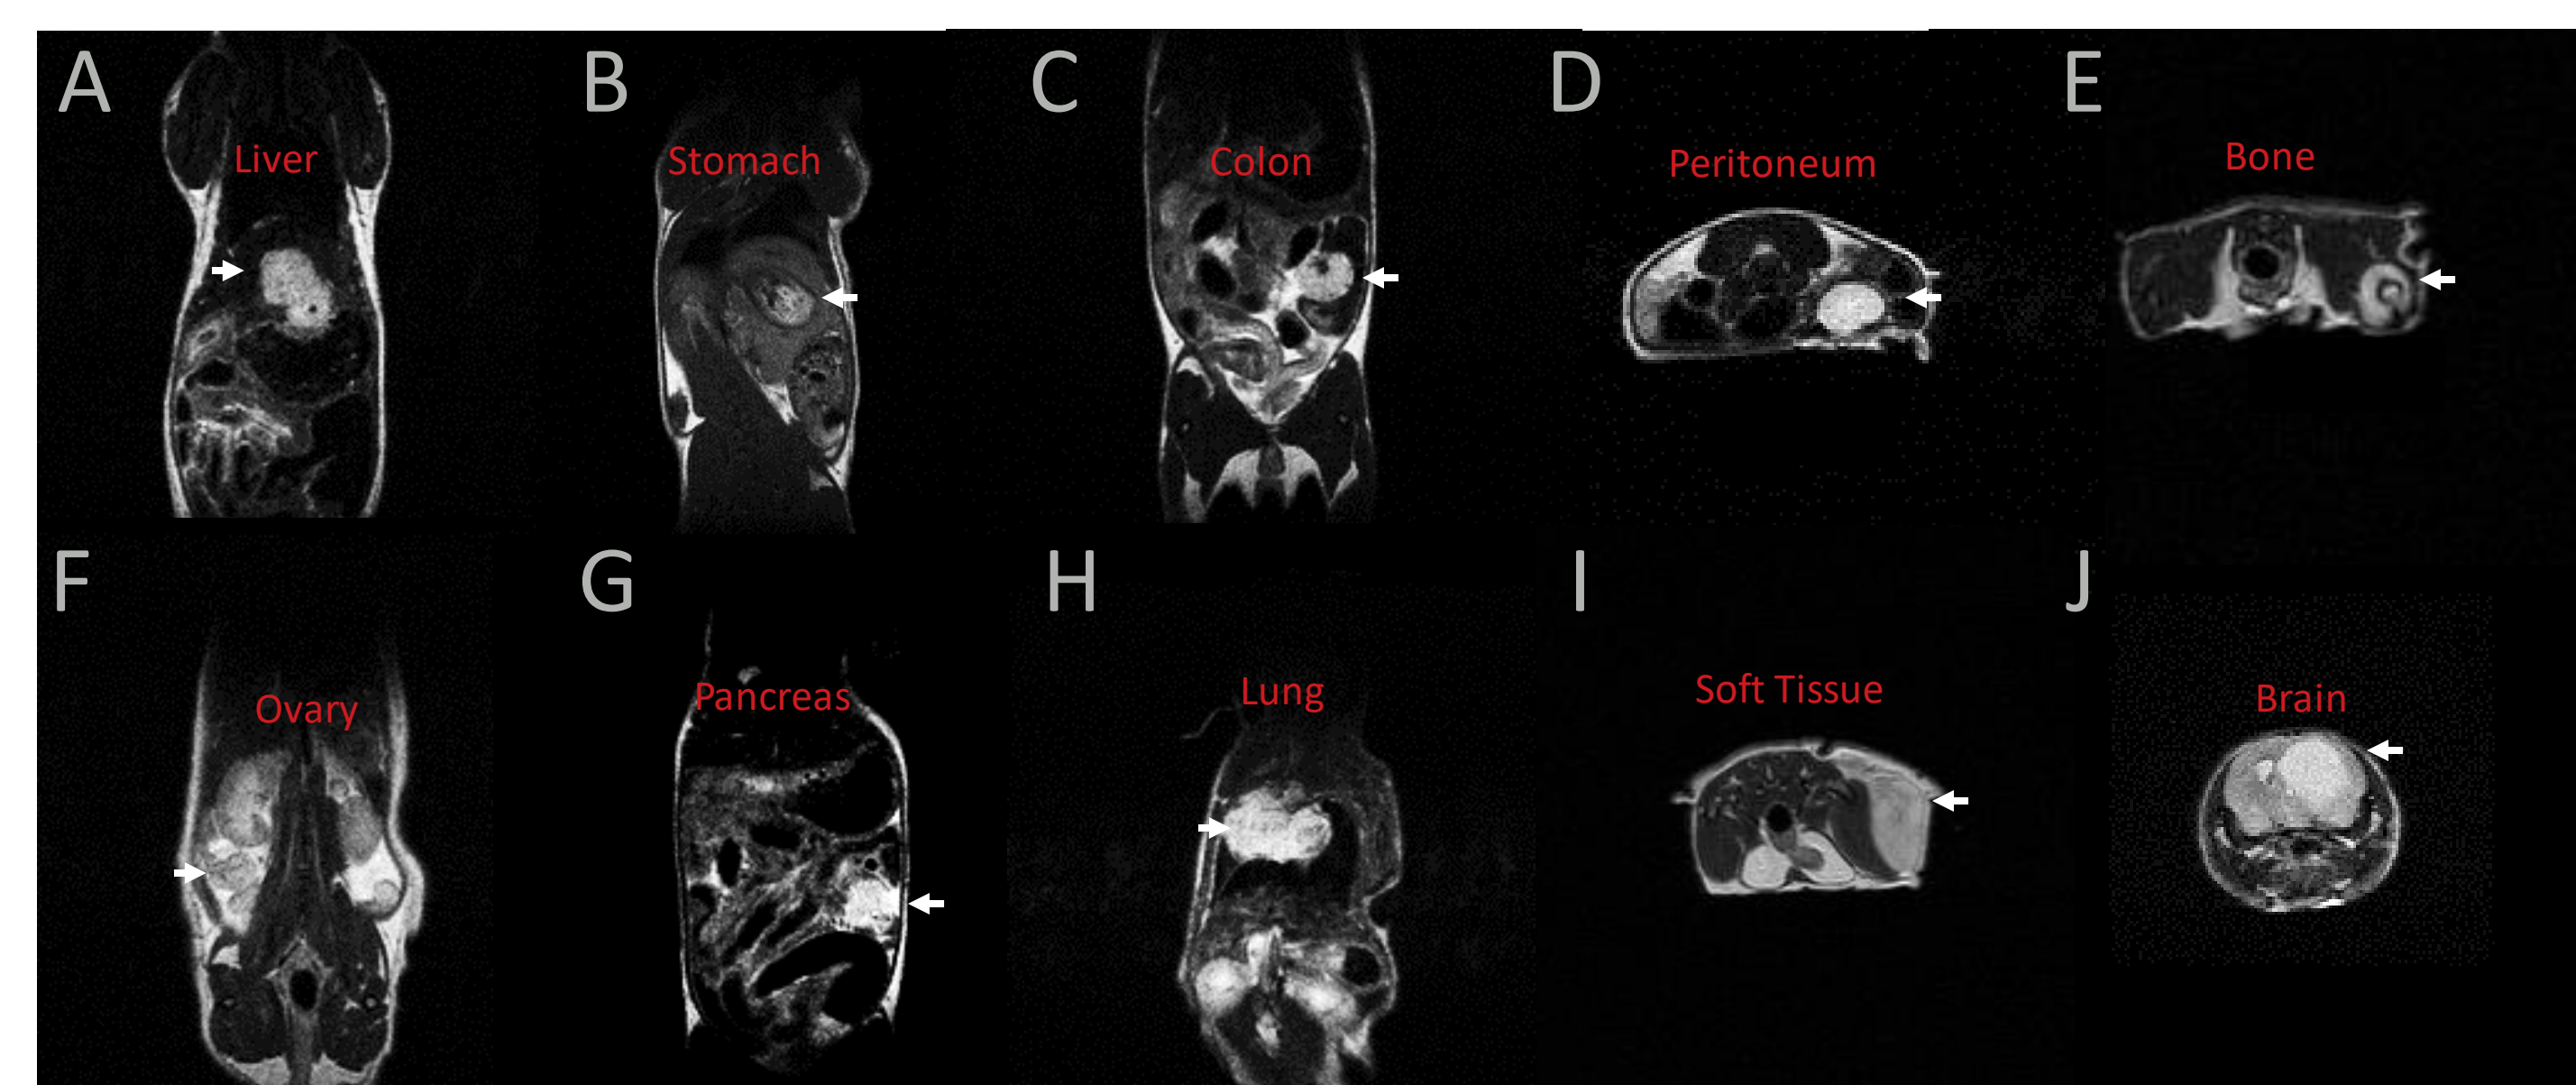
O-PDX implantation visualized by MRI. White arrow indicate tumor. A. Metastatic colorectal adenocarcinoma. B. Gastric adenocarcinoma. C. Colorectal adenocarcinoma. D. Liposarcoma. E. Osteosarcoma. F. Ovarian carcinoma. G. Pancreatic ductal adenocarcinoma. H. Lung adenocarcinoma. I. Myxofibrosarcoma. J. Glioblastoma multiforme.
